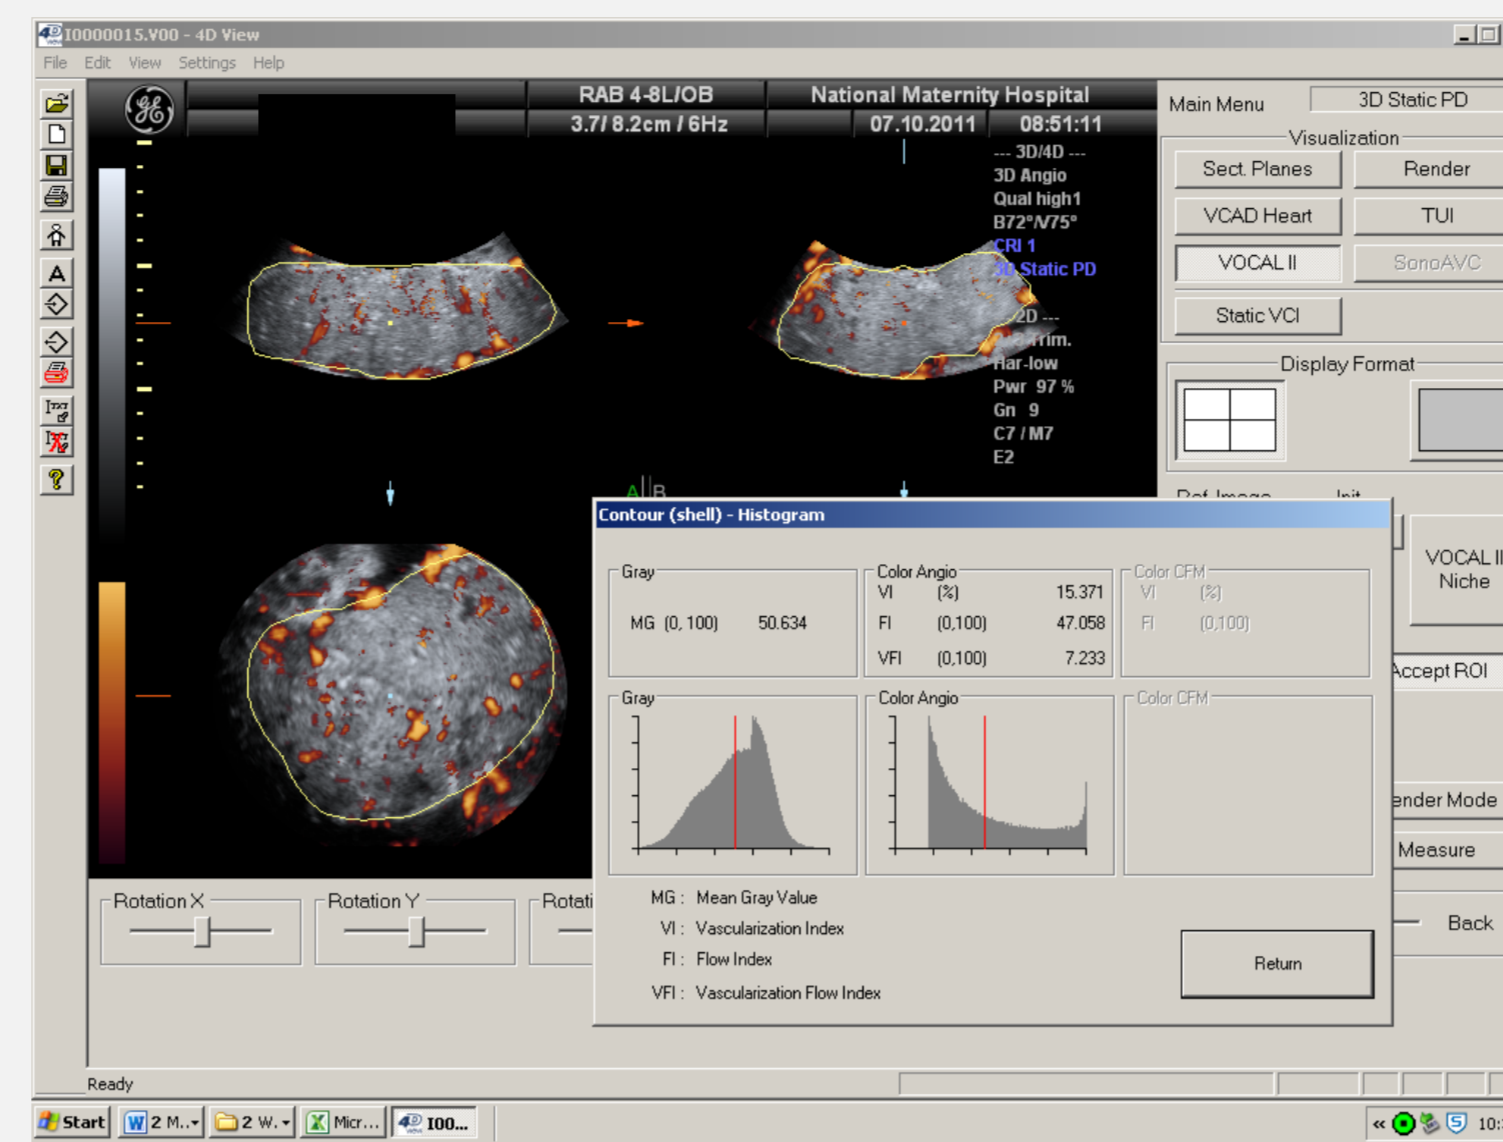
3D power Doppler histogram demonstrating the placental vascular indices [VI( 15.371%), FI (47.058) and VFI (7.733)]
